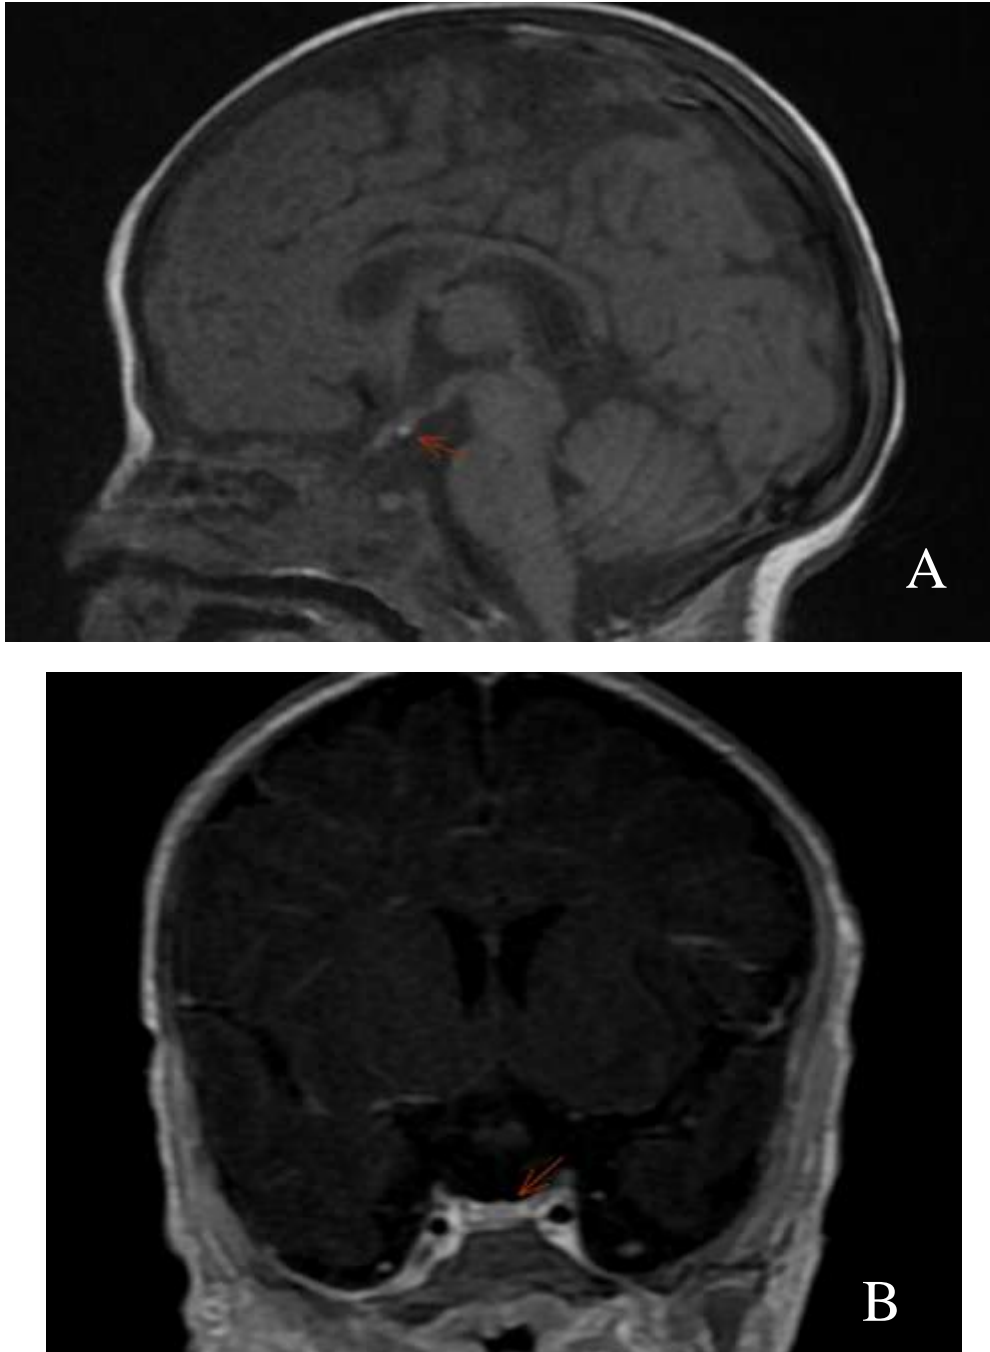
A: Sagittal T1 MRI image depicting a physiologically hyperintense posterior pituitary gland in an ectopic position at the level of the third ventricle floor. B: Coronal T1-weighted section post gadolinium injection showing a normal morphology and enhancement of the anterior pituitary gland, with no individualization of the pituitary stalk.
